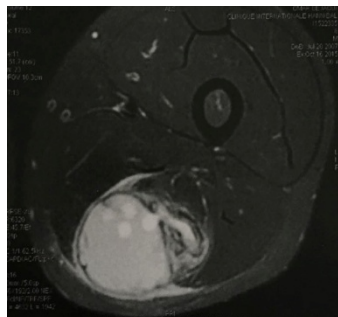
MRI showing the cystic lesion
